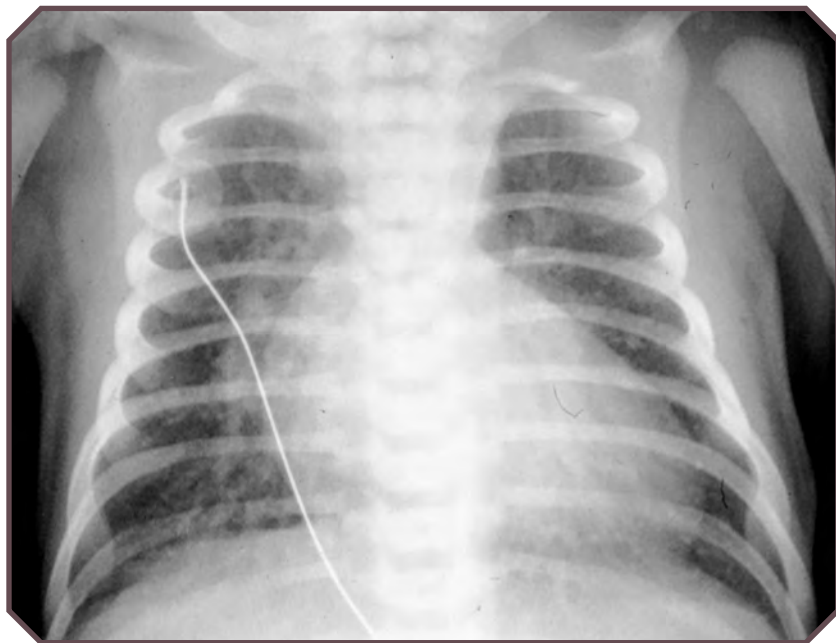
Transposition of the great vessels in a newborn with dyspnea. Frontal chest radiograph shows cardiomegaly and increased perihilar pulmonary vascularity (blood flow) typical for a right-to-left shunt.
